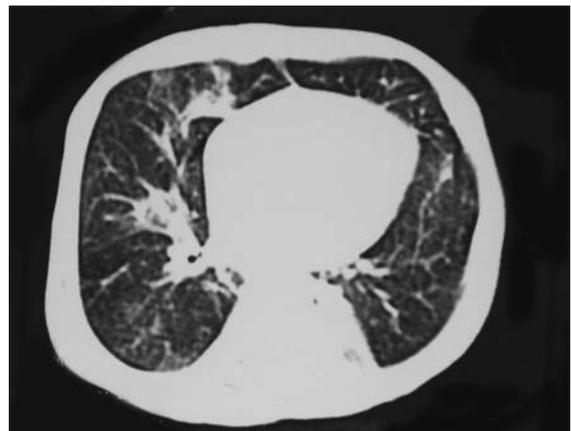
Chest computed tomography at diagnosis: bilateral pneumothorax all through the pleura.
